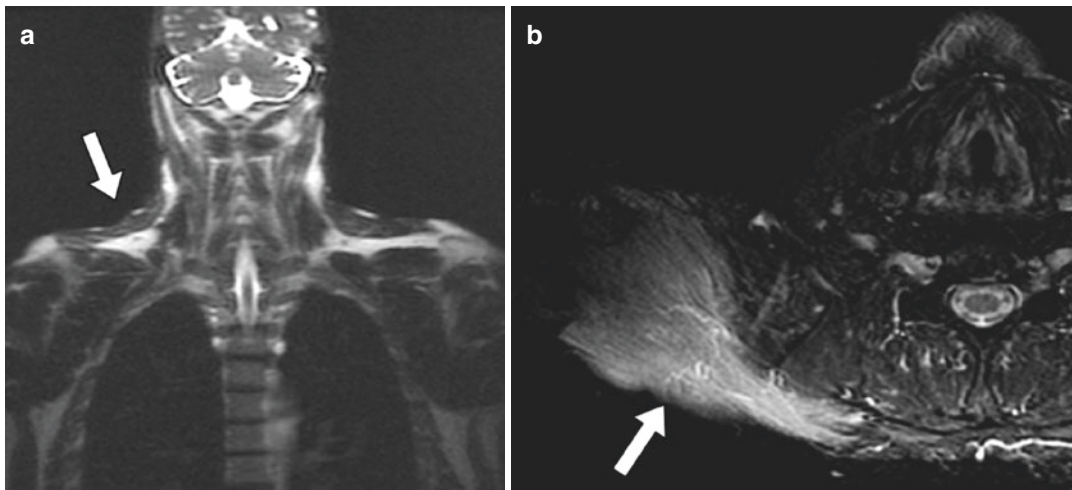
45-Year-old male with right-shoulder pain and weakness with scapular winging for a month. (a) Axial STIR and (b) coronal T1-weighted MRI show diffuse neurogenic edema involving right trapezius muscle (arrow)
